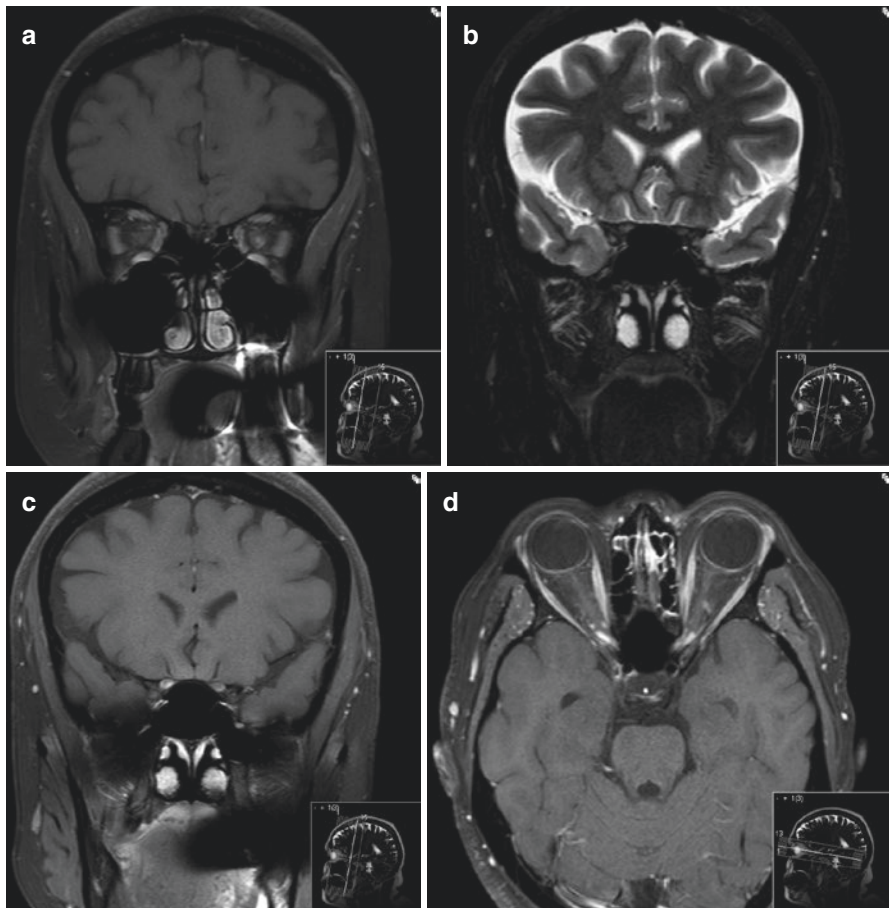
T2 weighted (a) coronal MRI showing high signal in both nerves and T1 weighted coronal and axial scans following administration of contrast, with swelling of the optic nerve – sheath complex within the posterior aspect of the orbit (b), enhancement of the right nerve (c) and enhancement of both nerves within the optic canals (d). There are no other abnormalities, in particular white matter lesions within the brain
